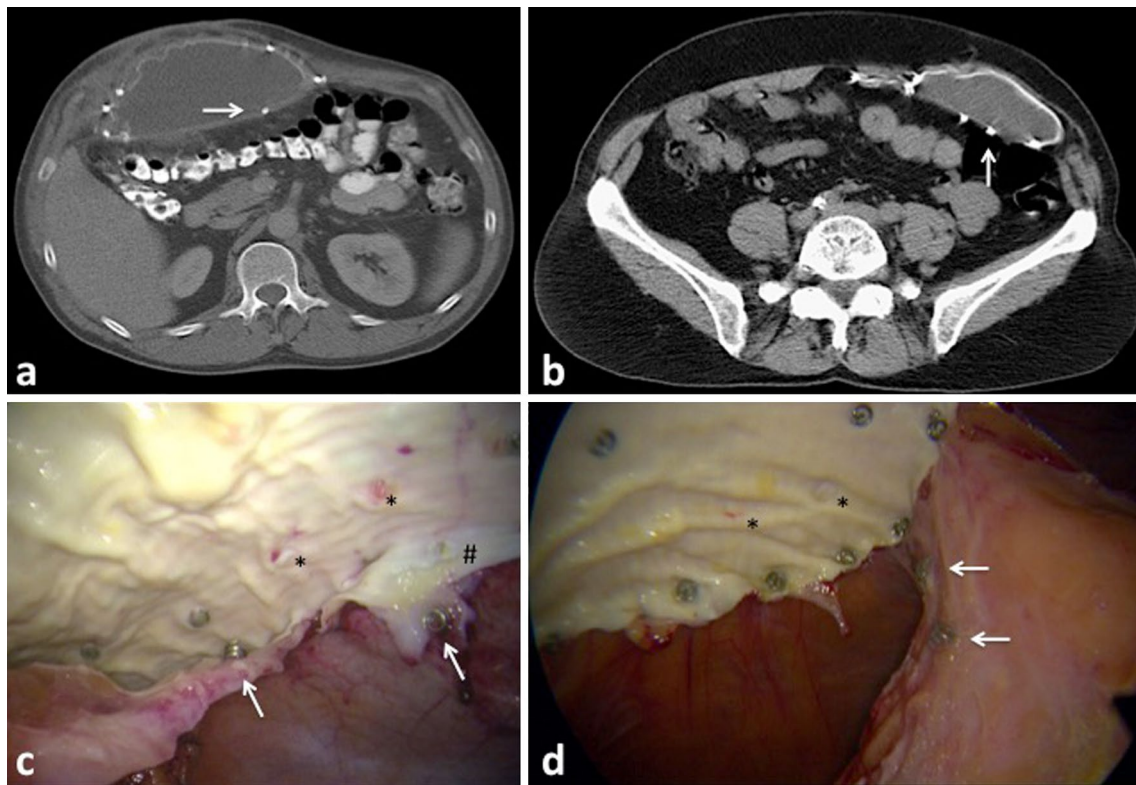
a, b Loose tacks from the inner ring as seen on a CT scan (arrows). c, d Tacks still held firmly in the thick neoperitoneum (arrows). Their imprint on the mesh was still seen at the inner ring (asterisk) as well as the outer ring (hash symbol)
